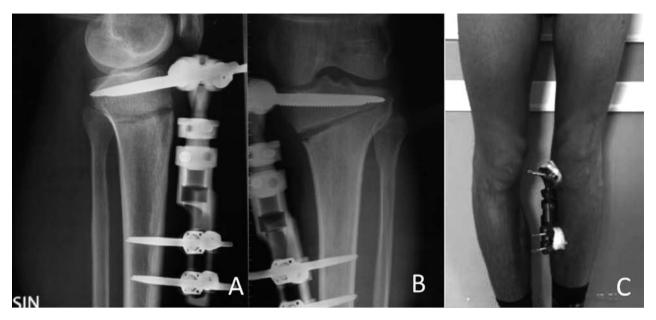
Radiographic (A-B) and clinical views (C) 30 days after osteotomy; satisfactory correction and initial bone callus formation
